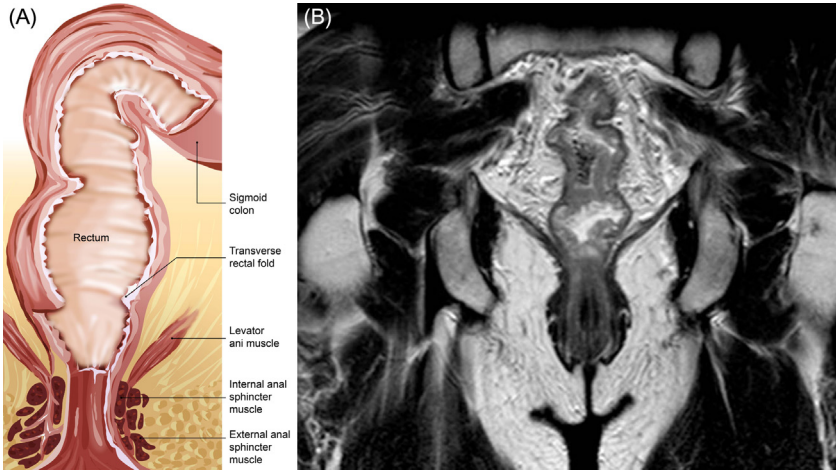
Anatomy of the anorectum: (A) The upper and middle third mainly function as storage space, whereas the lower third consists of the anal sphincter complex. The anal sphincter is a multilayered cylindrical structure, consisting of the smooth muscle internal sphincter and the external striated muscle layer. The sphincter is elevated by the funnel-shaped levator ani muscle [12]. (B) MR image of the anorectum. From (A) M. Scholle, (B) Courtesy: Dr. A. Fingerle, Klinikum rechts der Isar.
